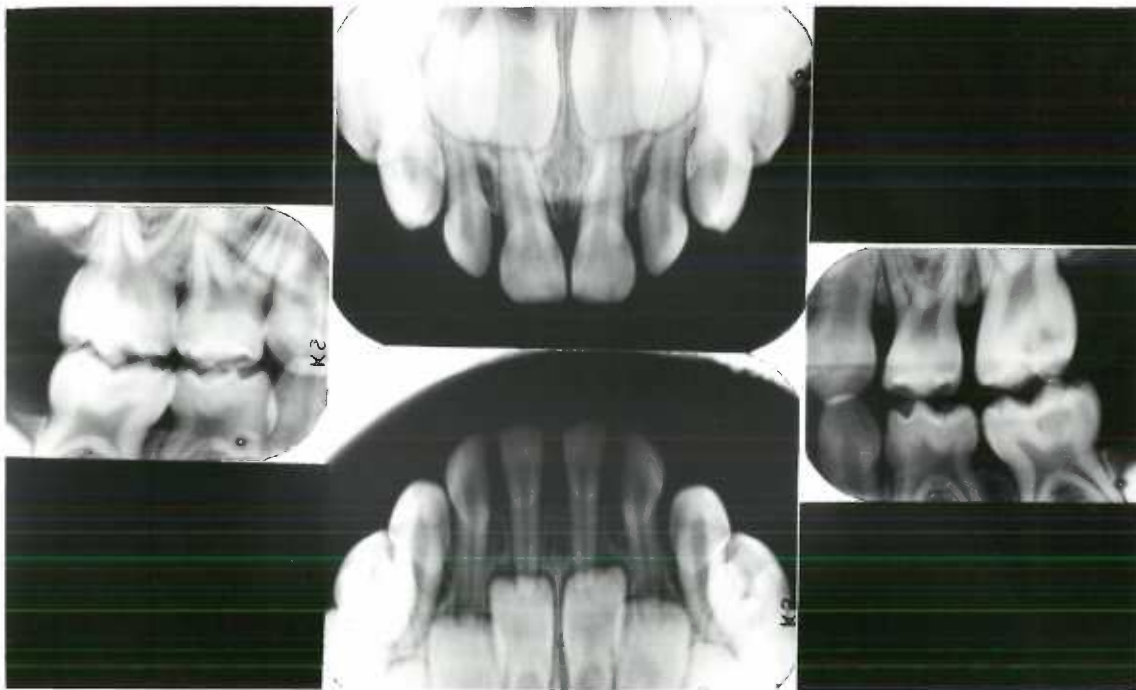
Patient 3. Age four years, radiographs show no alveolar bone loss.
